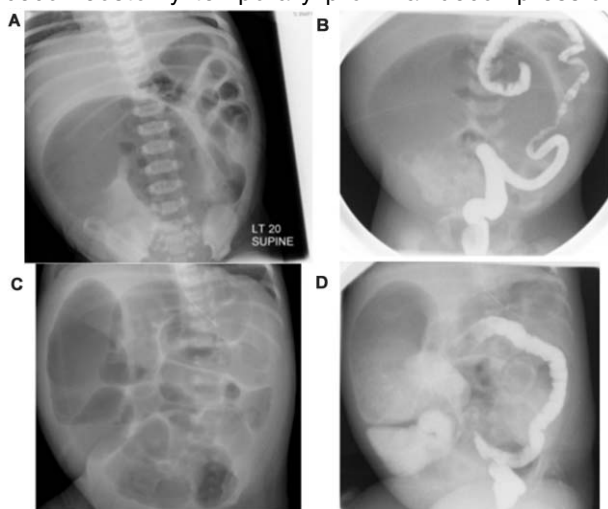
Pre and post operative Plain abdominal radiograph and contrast enema of case 3
